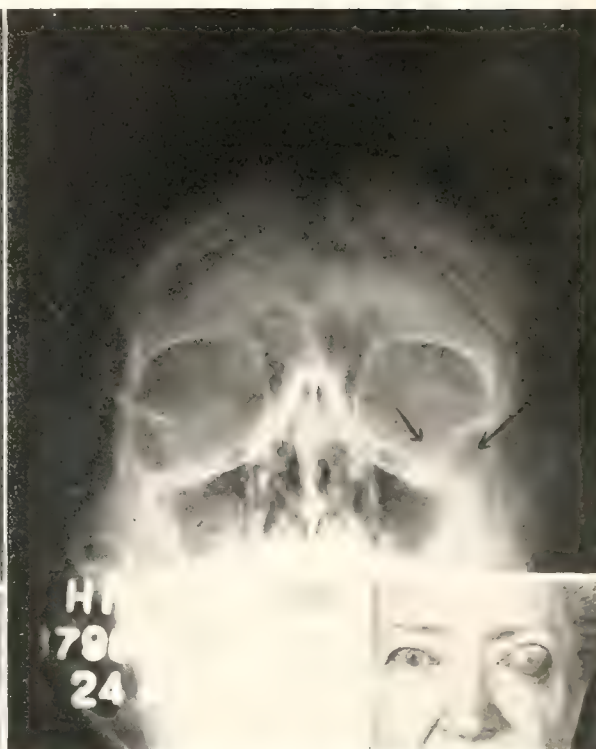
This patient had a twenty-year history of exophthalmos following an eye infection. The roentgenogram shows bony thickening of the floor of the orbit, apparently pushing the orbit up and outward.
